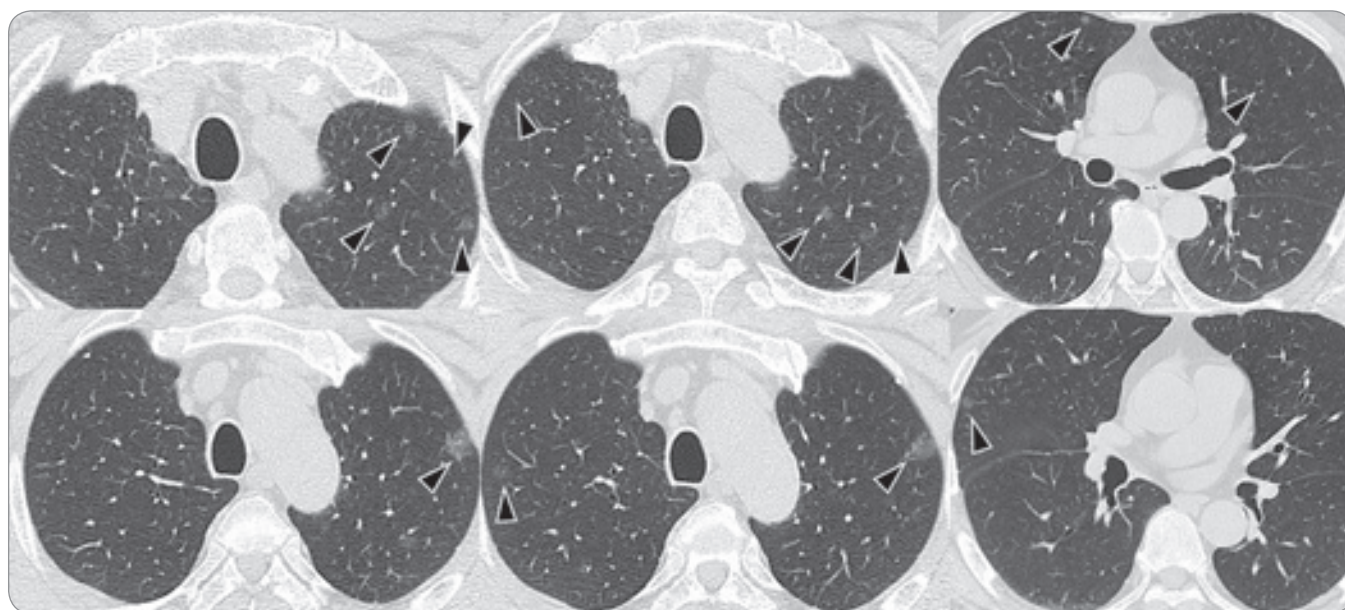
A chest CT scan showed numerous ground-glass opacity (GGO) nodules of various sizes in both lungs (arrows).
